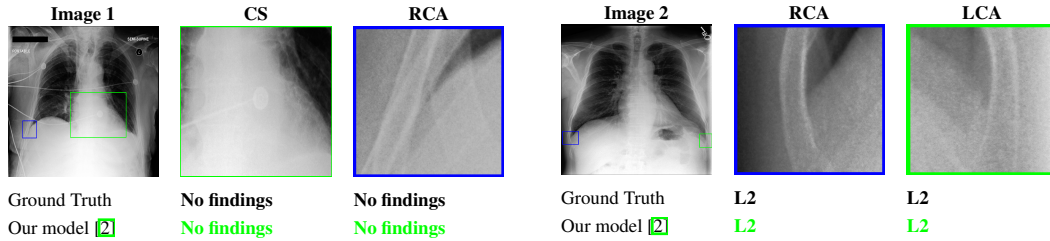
Examples of the prediction results. The overall chest X-ray image is shown alongside two anatomical regions, and predictions are compared against the ground-truth labels.
